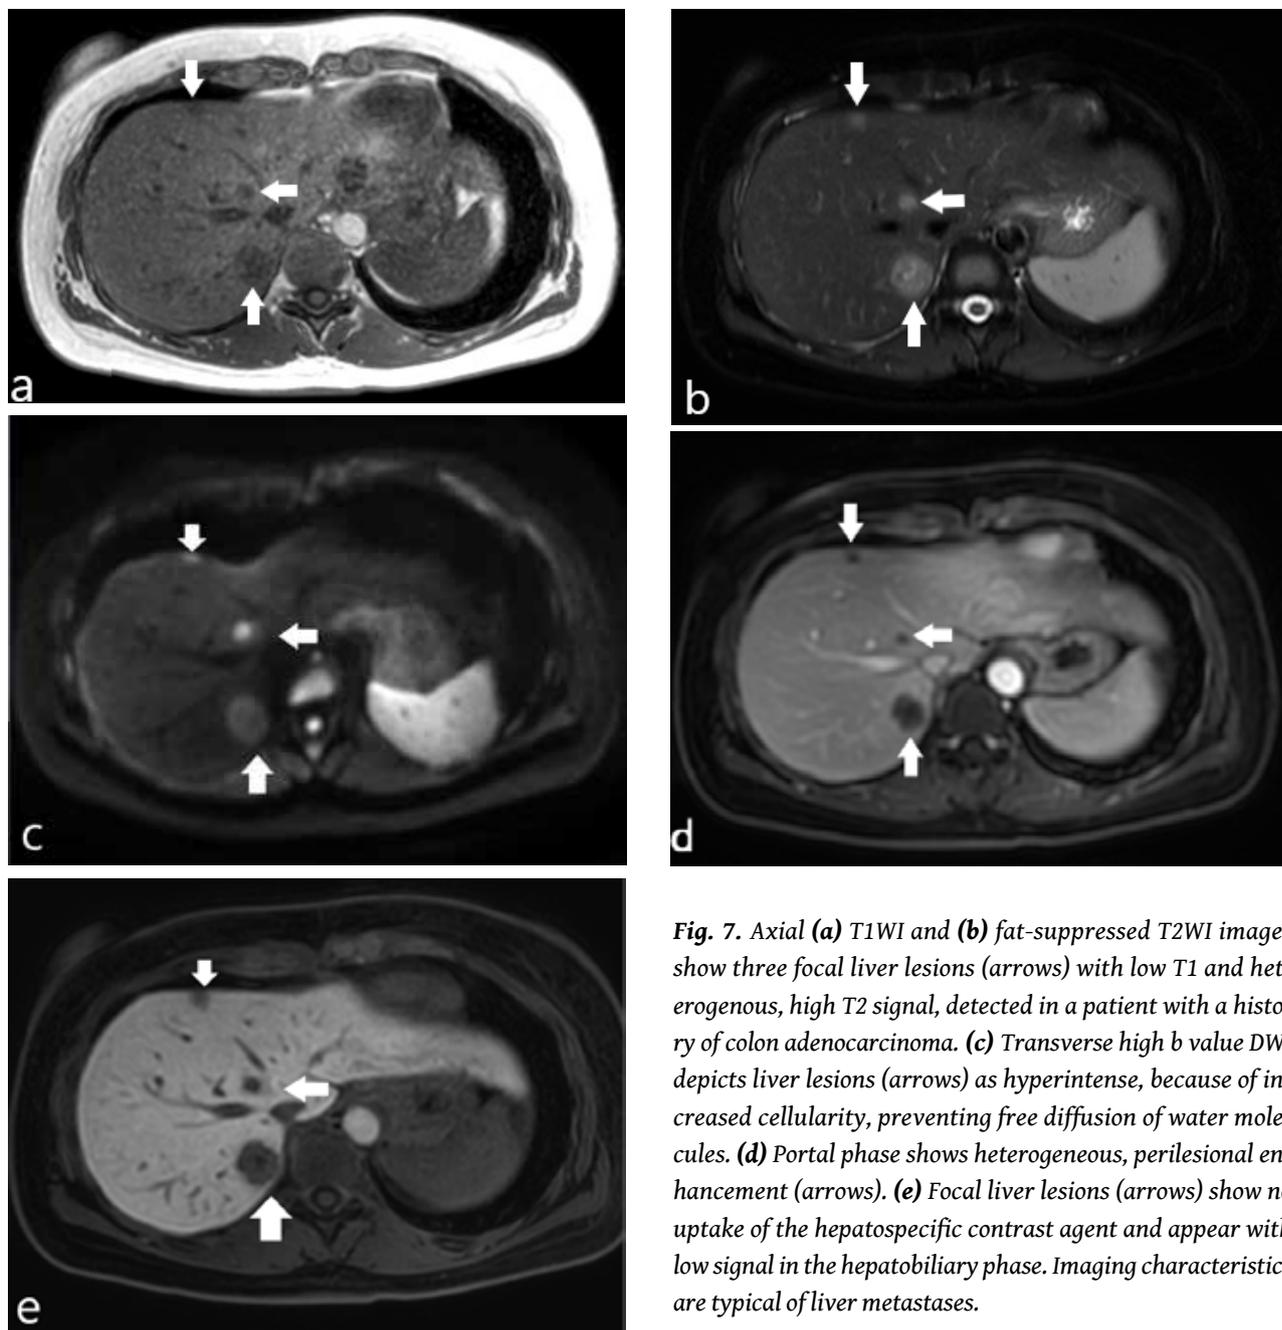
Axial (a) T1WI and (b) fat-suppressed T2WI images show three focal liver lesions (arrows) with low T1 and heterogeneous, high T2 signal, detected in a patient with a history of colon adenocarcinoma. (c) Transverse high b value DWI depicts liver lesions (arrows) as hyperintense, because of increased cellularity, preventing free diffusion of water molecules. (d) Portal phase shows heterogeneous, perilesional enhancement (arrows). (e) Focal liver lesions (arrows) show no uptake of the hepatospecific contrast agent and appear with low signal in the hepatobiliary phase. Imaging characteristics are typical of liver metastases.
